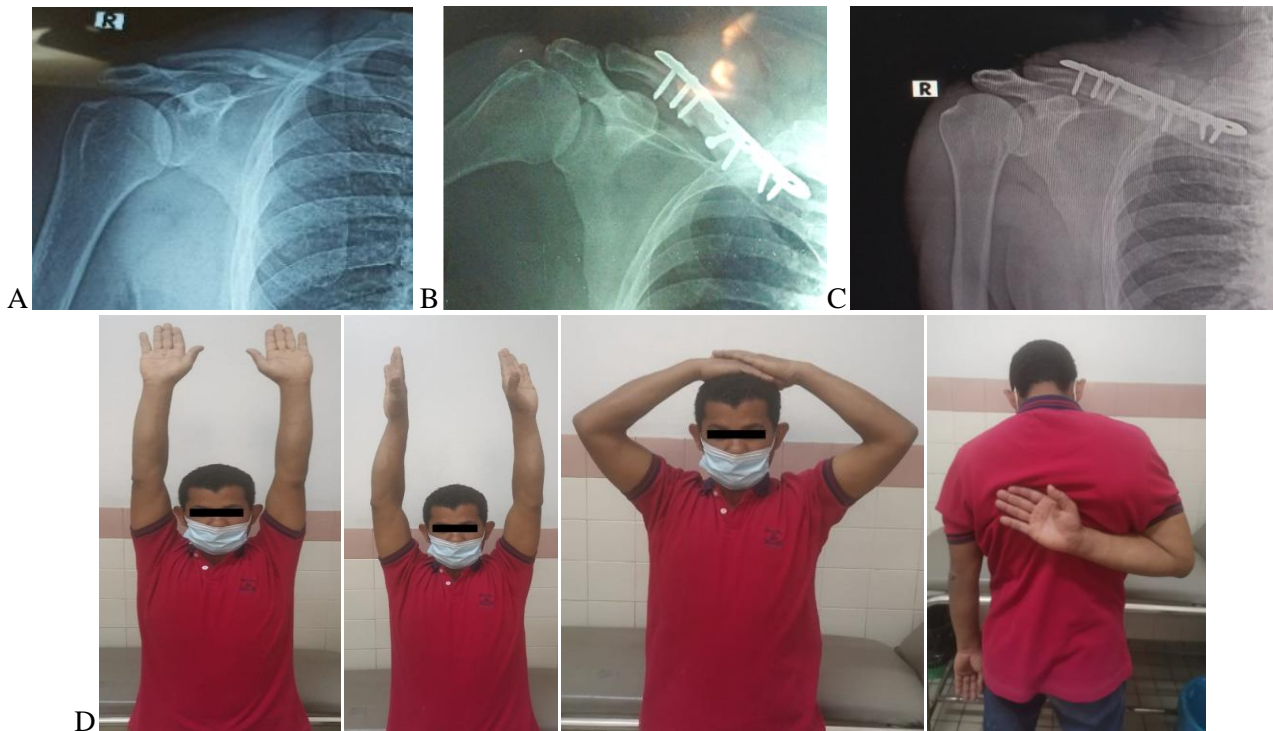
A thirty-three years old male, his occupation is a manual worker, has a fracture of the middle third of the right clavicle (Robinson type 2 B1) due to a direct fall on his right shoulder. Fixation with a precontoured locked plate was done after one day. A: preoperative X-ray. B: Immediate postoperative. C: X-ray after six months shows complete union. D: full active forward elevation, abduction, external rotation and internal rotation. The final score was 100 and the grade was excellent.
